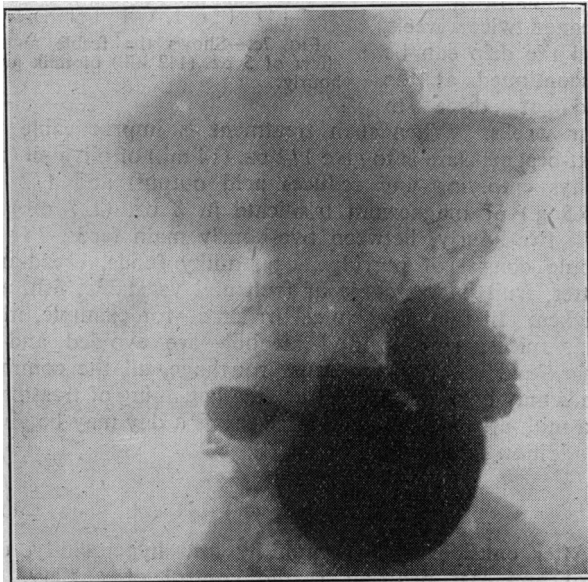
Chronic duodenal ulcer with clinical signs of stenosis. This is masked in the radiograph because of powerful peristalsis.
